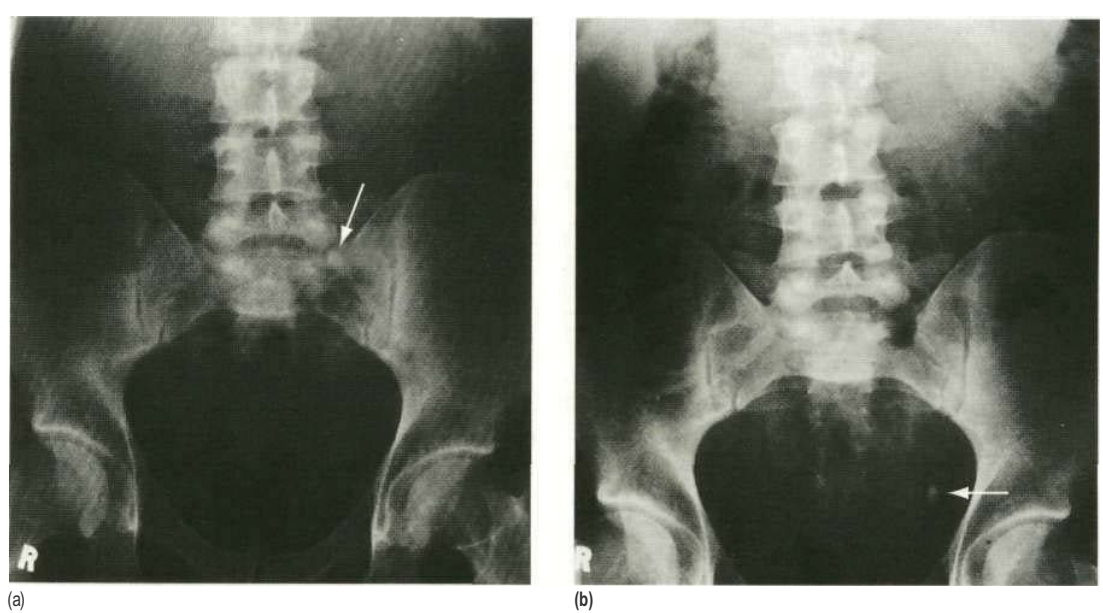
X-rays showing calculus, (a) The calculus (arrow) is overlying bone on the left (easily missed), (b) The same patient 1 week later: the calculus has descended and is easily seen in the pelvis of the left side (arrow).
